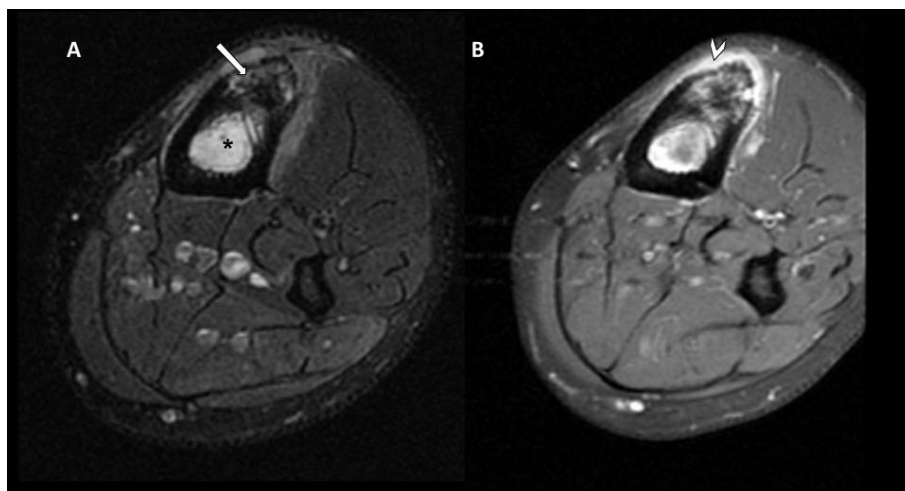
A) Axial proton density sequence magnetic resonance imaging and B) fat-saturated contrast-enhanced T1-weighted images. Bone marrow signal alteration (*), hyperintense in proton density sequences, thickening of the anterior cortex of the tibia with patchy areas of lower intracortical bone density (arrow) and soft tissue component enhancing after contrast administration (arrowhead).
